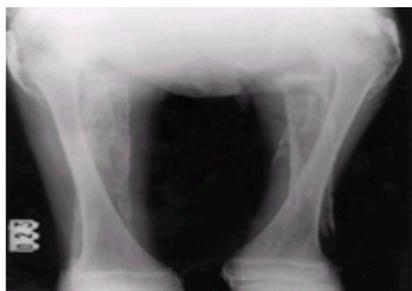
Dermatomyositis in a 7-year-old girl. Plain film of extensive calcinosis in the subcutaneous tissue and in the muscles.
